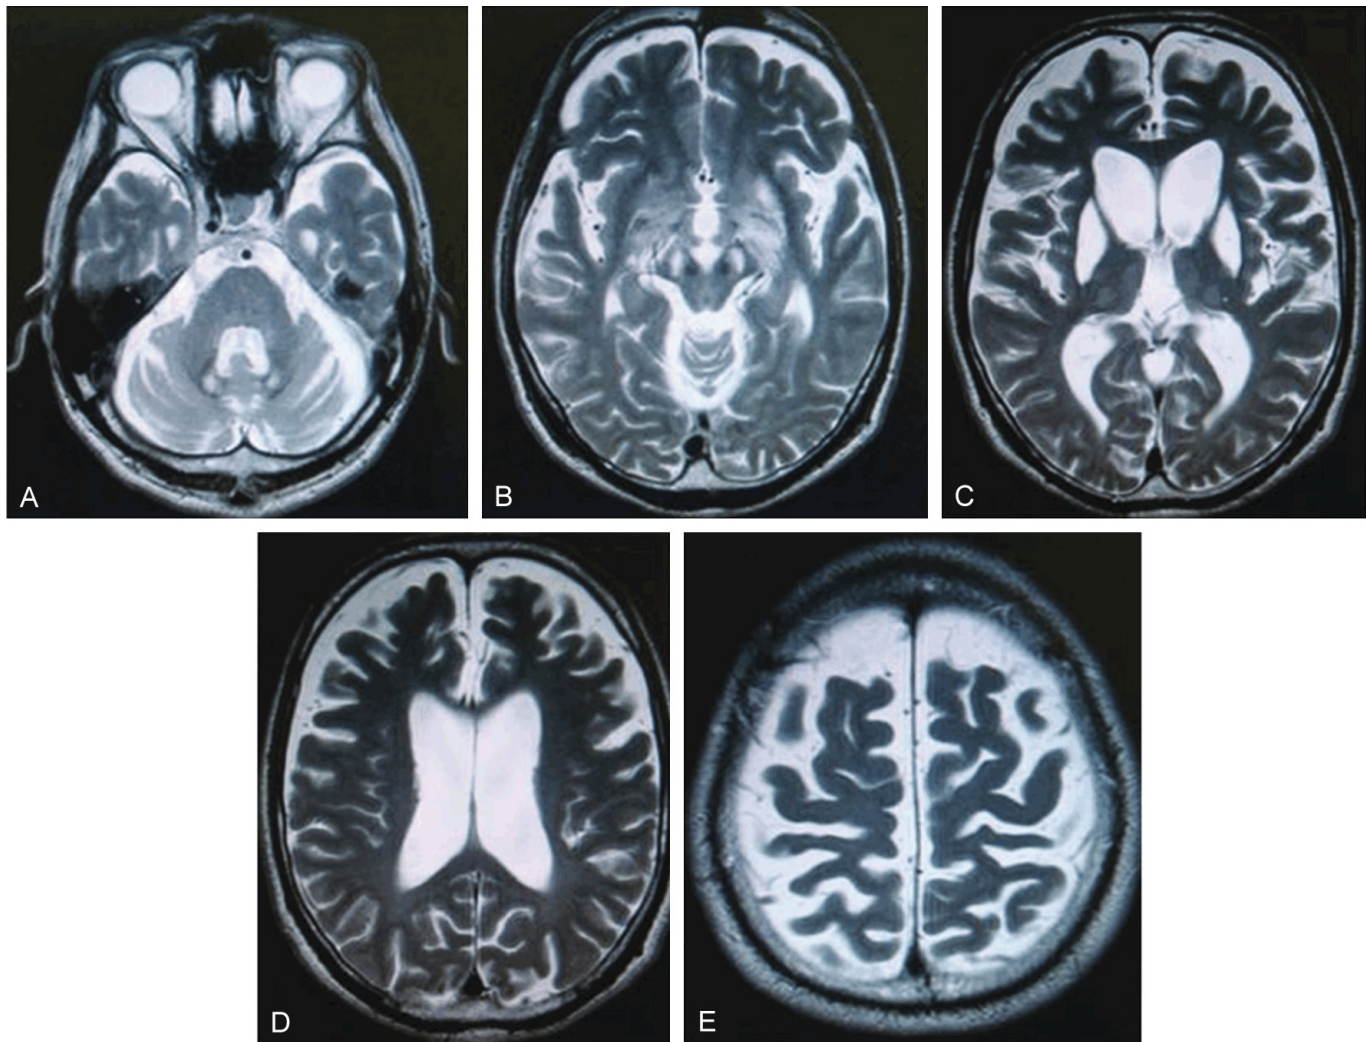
T2-weighted MRI scans (TR 3,440 ms/TE 89.4 ms) of a 42-year-old patient show specific neuroimaging findings. A. A cross-sectional view at the pontine level displays bilateral, symmetric signal loss with central hyperintense abnormalities in the dentate nucleus, along with cerebellar cortical atrophy. B. The midbrain section reveals symmetric high signal intensity in the substantia nigra and a reduced signal change in the red nucleus. C. At the level of the basal ganglia, there is a hyperintense signal surrounded by a hypointense band affecting the putamen and pallidum, along with hazy high signal changes in the bilateral inner thalamus. D. A section through the central lateral ventricles is shown. E. A cerebral cortex section indicates no evident signal changes. Reproduced from MRI findings in neuroferritinopathy. *Neurology research international*. 2012;2012(1):197438. ©2012, with permission under Creative Commons Attribution 4.0 International Public License (<https://creativecommons.org/licenses/by/4.0/legalcode>) [6].
